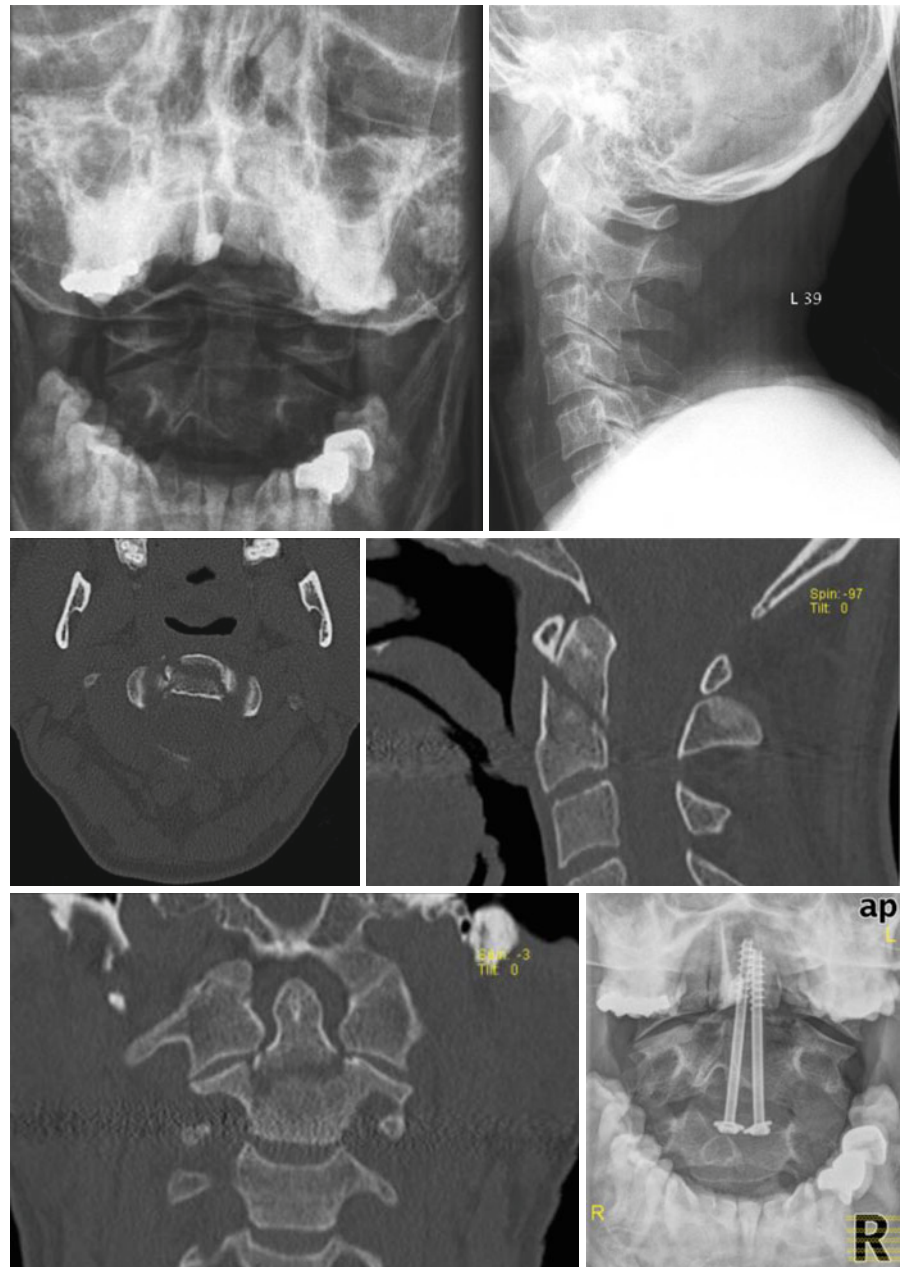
Forty-six-year-old patient after fall on his head. Type-II fracture according to Anderson/D'Alonso, preoperative X-rays and CT, operative treatment with two anterior lag screws, postoperative X-rays
